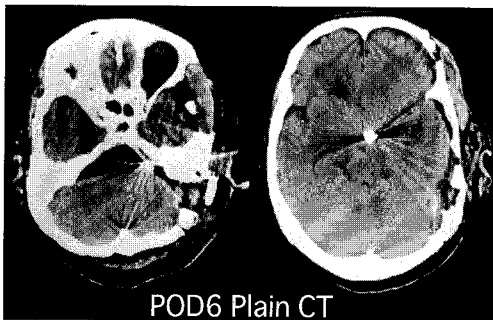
The patient of Fig. 5. recovered from general anesthesia smoothly without delay. The postoperative CT showed no abnormal findings. The mild hypothermia had to protect the brain from ischemia during temporary clamp, which was placed as long as 30 min.
